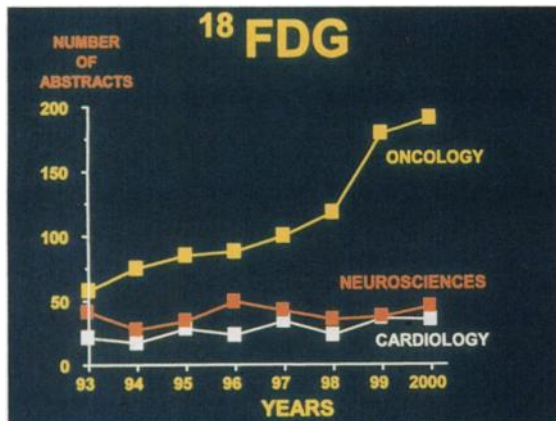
Continuing increase in ¹⁸F FDG presentations in oncology.
